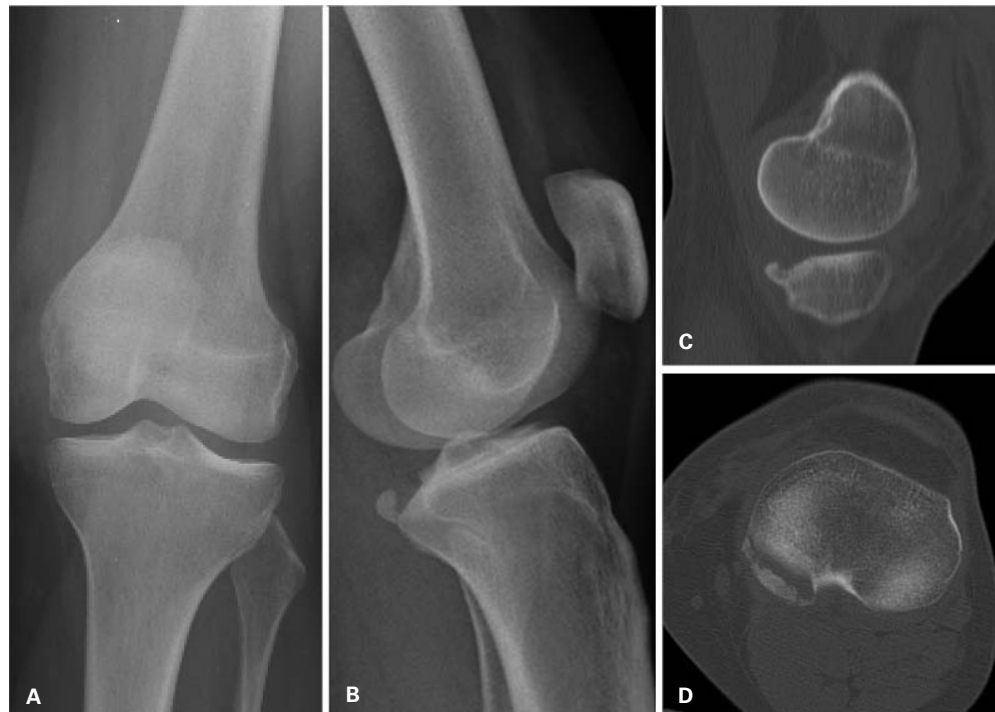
Anteroposterior (A) and lateral (B) plain radiographs and sagittal (C) and axial (D) computed tomography scan cuts demonstrating a pure depression-type posterior tibial plateau fracture in a 33-year-old female.
